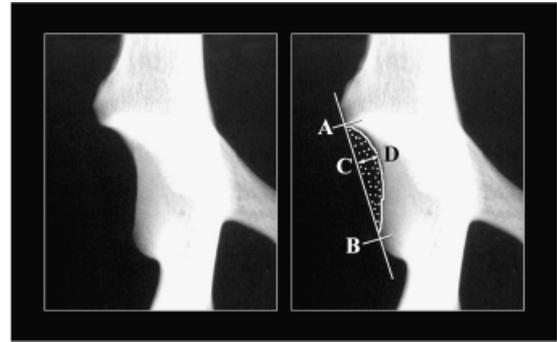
Ventrodorsal radiograph of right acetabulum. Note the cranial aspect of the acetabulum (A), caudal aspect of the acetabulum (B), point of maximum dorsal acetabular edge (DAE) depth (D), and the point of perpendicular intersection of a line from D to line AB (C). The lengths AB and CD were measured and expressed as a ratio. The acetabular defect area is the shaded region between the line AB and the DAE.
